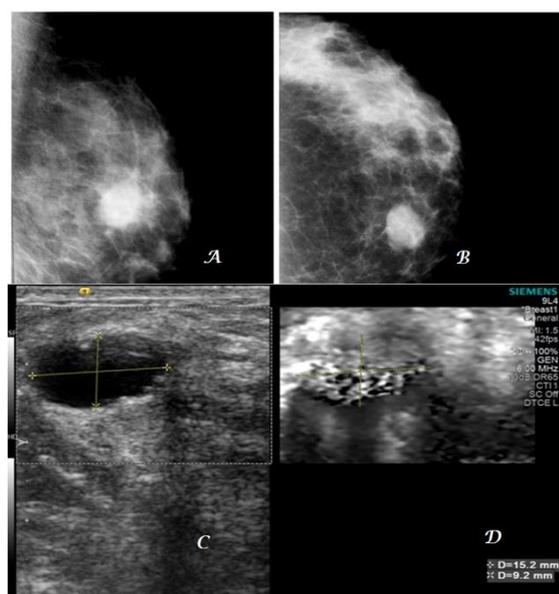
X-ray mammogram of bilateral breasts showing both CC (A) and MLO (B) views reveals a radio-opacity with lobulated margins and in close proximity to the chest wall in the inferomedial quadrant of right breast. B-mode scan image (C) shows presence of ill-defined hypoechoic lesion which on VTI (D) shows relatively hard lesion seen as black area in the field of view. On subsequent VTTQ (E) shear wave velocity within the lesion and in surrounding parenchyma show x.xx m/sec values suggesting hard lesion favoring malignant nature.
